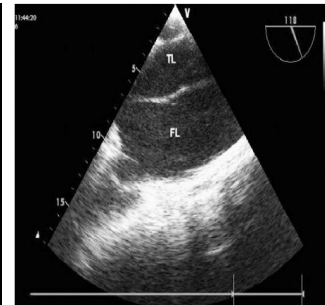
Transesophageal echocardiography revealed double-barrelled aorta and dilation in ascending aorta. TL (True lumen) FL (False lumen).
